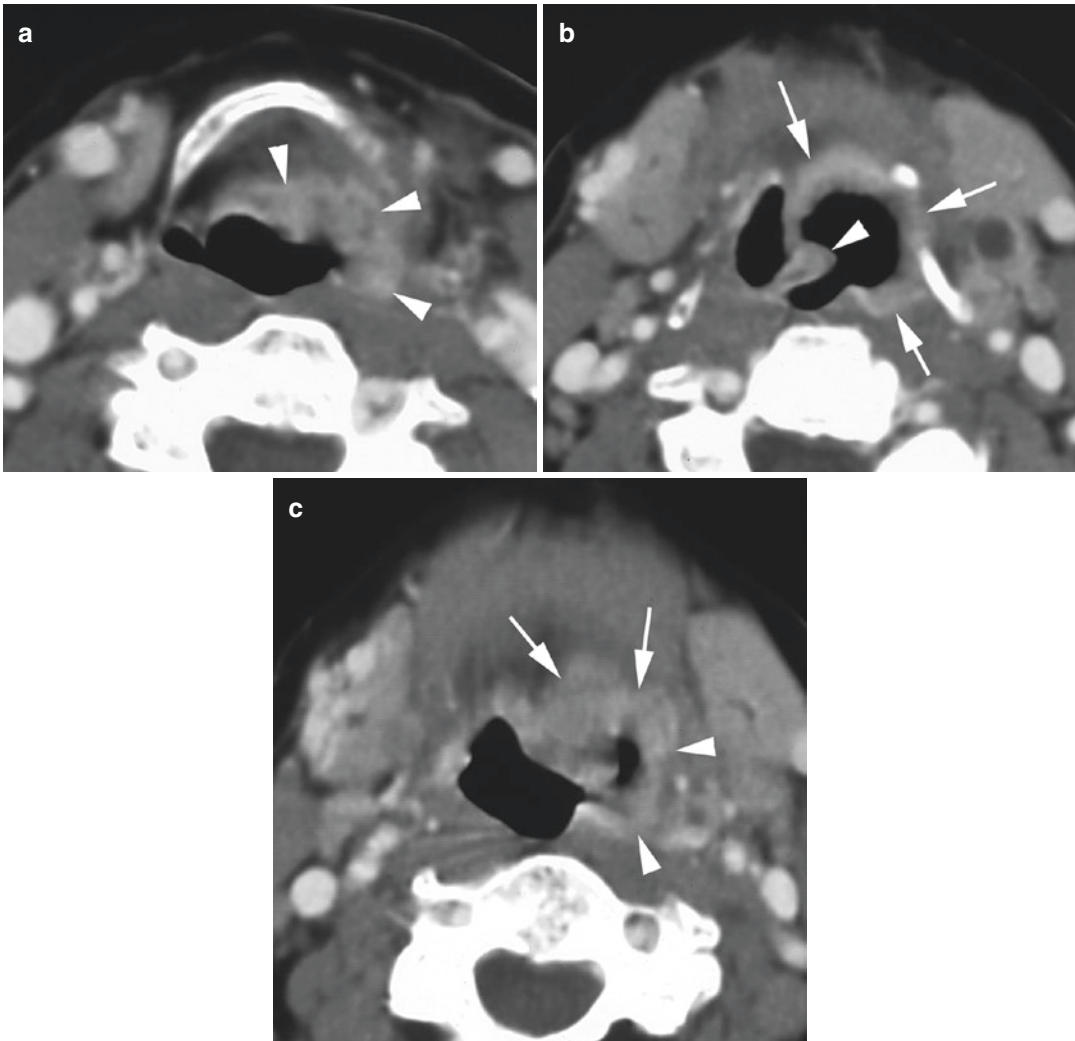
Contrast-enhanced axial CT images in a patient with a supraglottic squamous cell carcinoma. (a) Level of hyoid bone. Thickening and increased enhancement of the epiglottis, as well as infiltration of the preepiglottic and paraglottic space, with extension into the left aryepiglottic fold, is seen. Involvement of the upper part of the left piriform sinus cannot be excluded. (b) Level of free epiglottic
